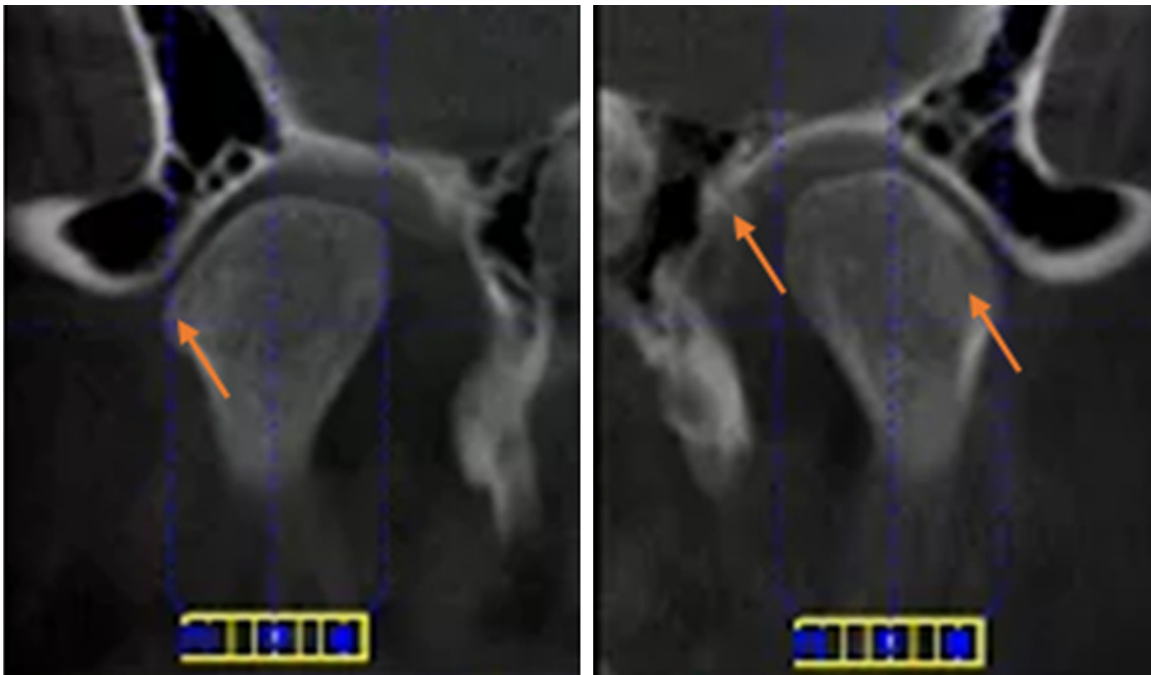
CT images of Female 52 years old. Left hand side: right condyle. Right hand side: left condyle. Osteophyte in the right condyle. Condylar erosion and bone erosion on left temporal.
